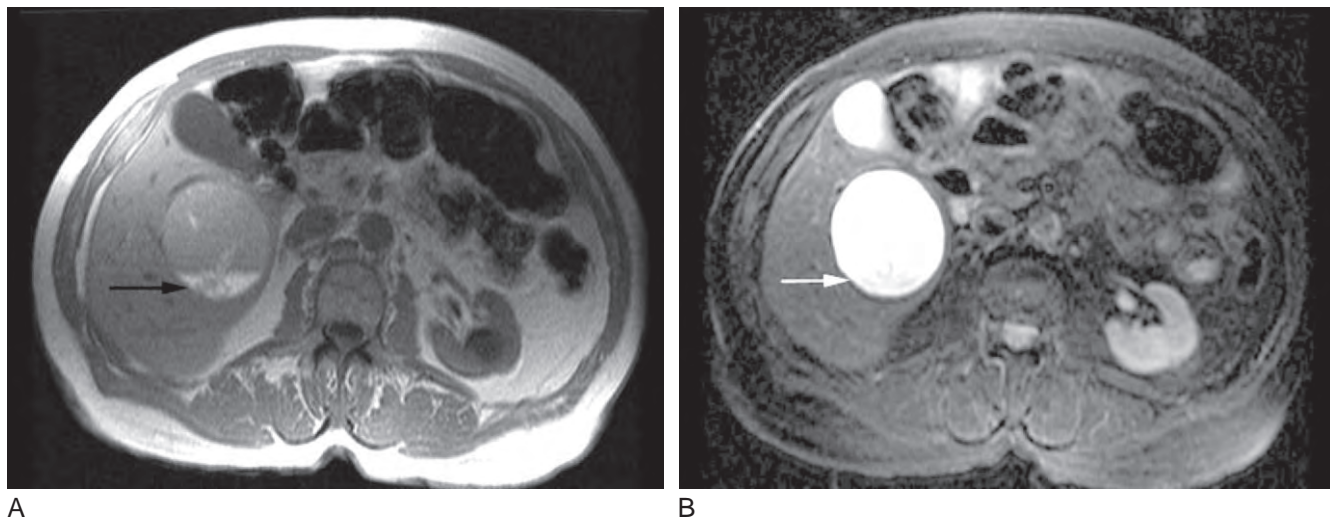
Hemorrhage within a simple cyst. Transverse T1-weighted (A) and T2-weighted (B) MR images show a high attenuation content of the cyst on T1-weighted and T2-weighted imaging with layering high T1-weighted and low T2-weighted signal intensity material (arrows) in the dependent portion of the cyst indicating the presence of hemorrhagic products (methemoglobin).
